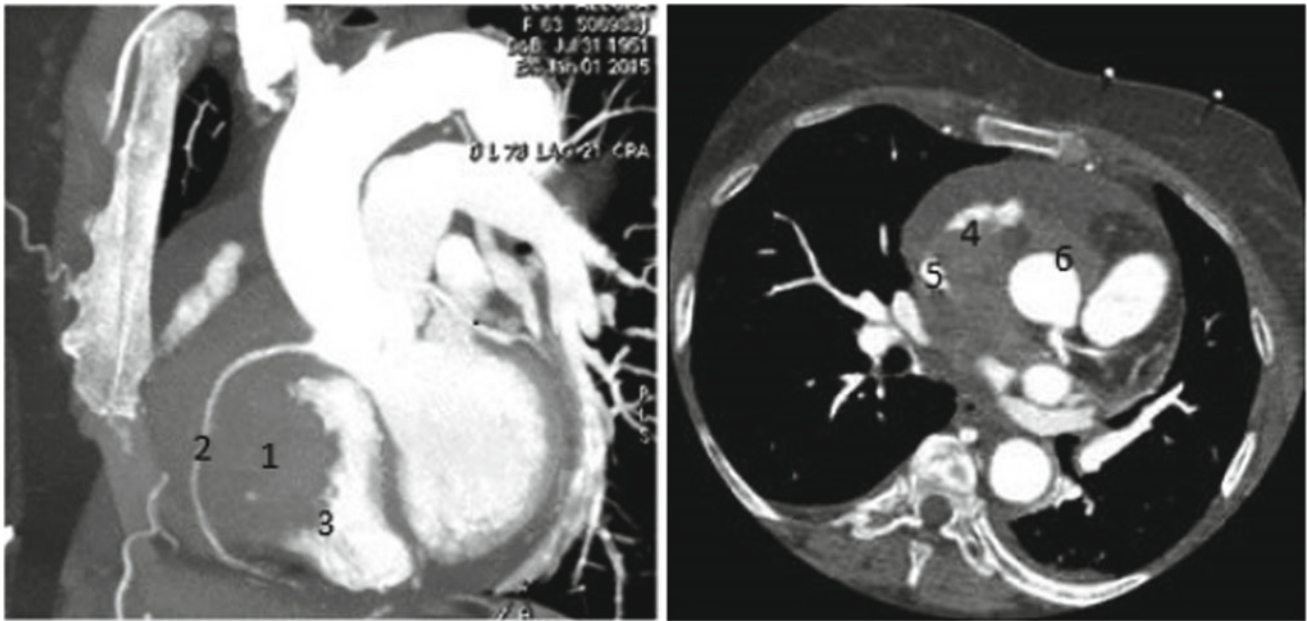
Left and right panels, Cardiac computed tomography performed during patient's initial presentation demonstrating a homogenous mass involving the right ventricle. The mass dimensions were measured 85 mm * 53 mm * 90 mm. The mass is anterior to the atrioventricular groove encasing the right coronary artery but not
